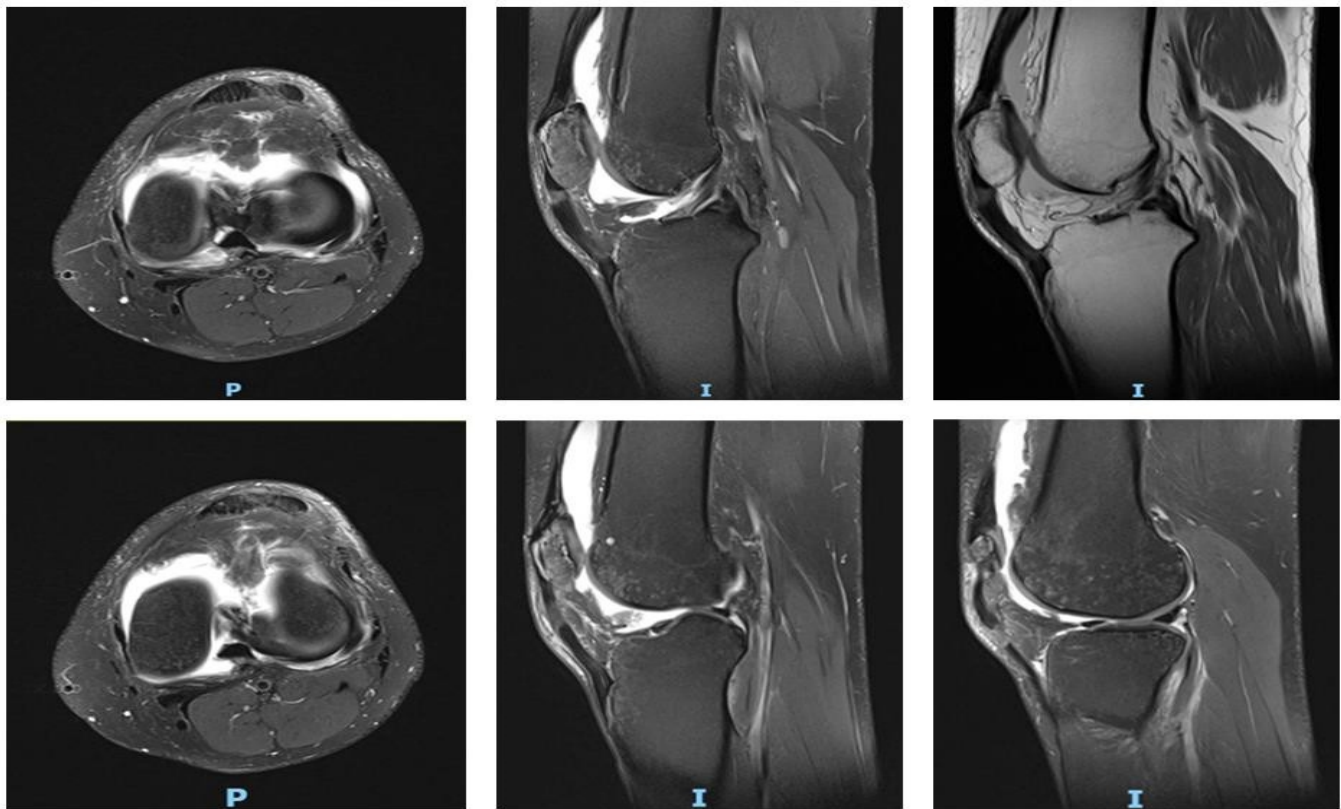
Magnetic resonance imaging in DP FATSAT axial planes; sagittal T2 FATSAT and sagittal DP where a tear of at least 70% in the patellar tendon is identified, as well as abundant joint fluid that communicates to the suprapatellar bursa.
